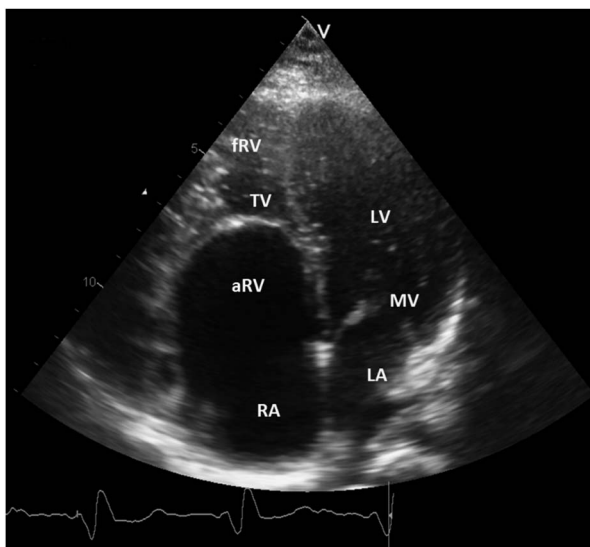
Echocardiographic feature of a patient with Ebstein's anomaly demonstrating the apical displacement of the TV, dividing the right ventricle in an atrialised (aRV) and a functional portion (fRV). LA = left atrium; LV = left ventricle; MV = mitral valve; RA = right atrium; TV = tricuspid valve.
